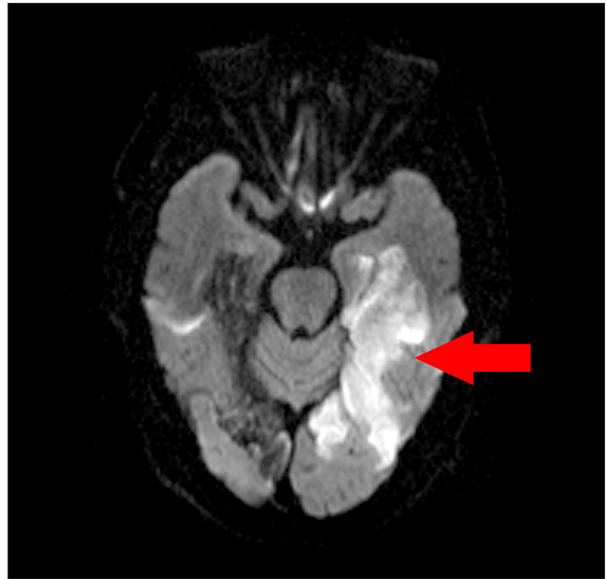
Axial diffusion-weighted magnetic resonance imaging scan obtained at the time of the recurrent event. New areas of restricted diffusion (high signal intensity) are present in the left temporal and occipital lobes, indicating acute infarction. These lesions are nearly symmetric to the prior right-sided infarcts shown in Figure 1.
